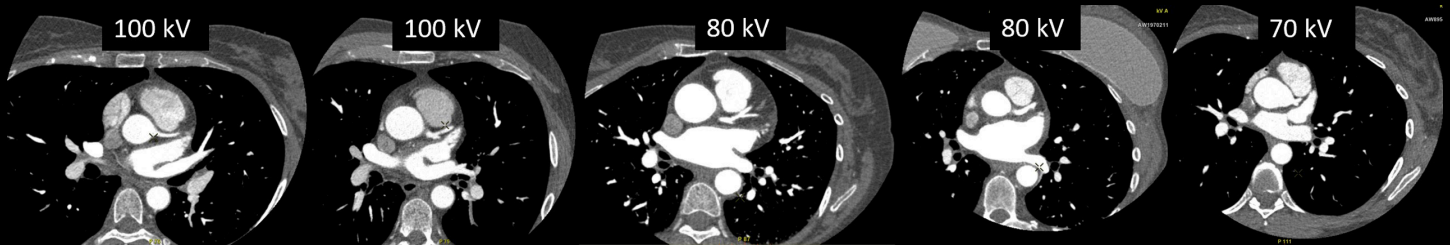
CCTA images for large patients acquired on Revolution CT without Auto Prescription (top row) and on Revolution Apex with Auto Prescription (bottom row). Images acquired with Auto Prescription tended toward lower kV with subjectively similar image quality. WW/WL values for the images in the top row are 800/100. WW/WL values for images in the bottom row are 870/110 (100 kV), 960/115 (80 kV), and 1100/140 (70 kV).
